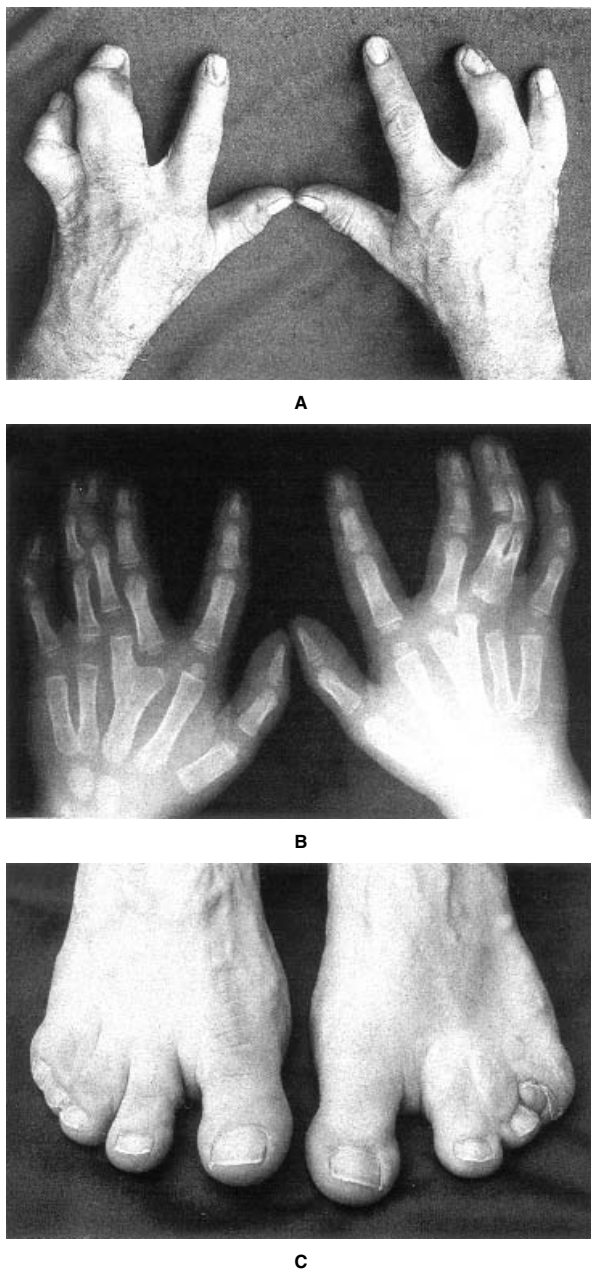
Synpolydactyly. (A) Complete membranous and partial osseous fusion of fingers III and IV with an additional finger in the syndactylous web. Frequently, as in this patient, complete cutaneous fusion of finger III, the extra finger and finger IV is observed resulting in a single nail. (B) Radiograph of hands of an affected child age 10 showing V-shaped metacarpal III, polydactyly between fingers III and IV, and hypoplastic middle phalanx of finger V. (C) Feet of individual in (A) showing cutaneous syndactyly of toes V to III/II. The fifth toes are broad and duplicated.
